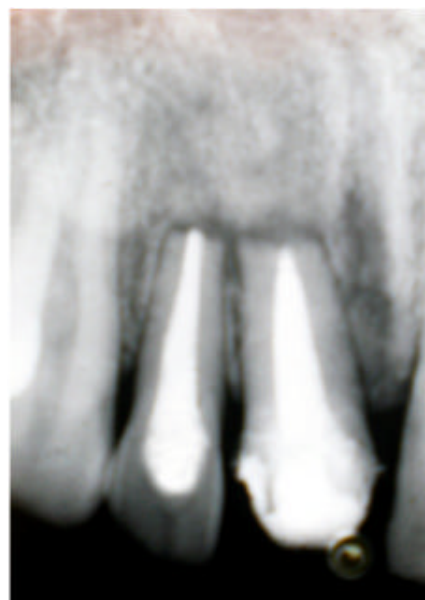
Intra-oral periapical radiograph after 2 years follow up showing good periapical bone
